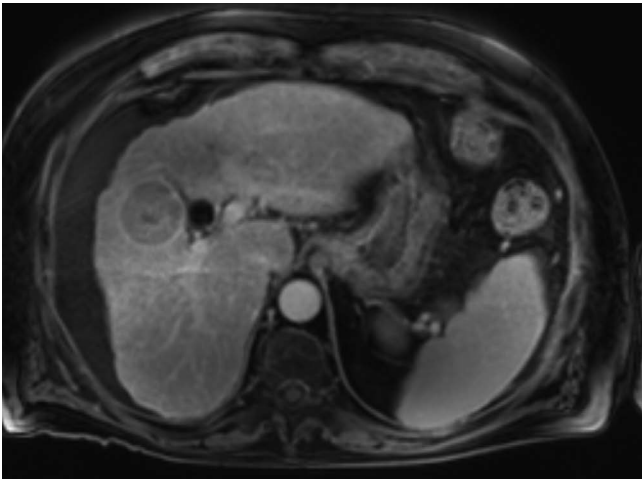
Liver. MRI. T1 weighted. Fat suppression. Contrast enhancement. Delayed phase. Axial plane.
